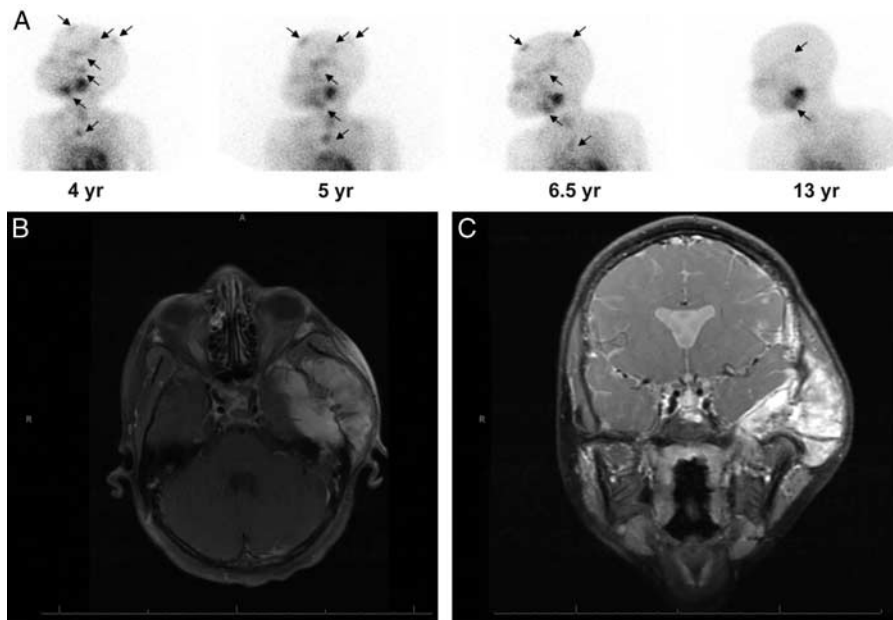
Imaging follow-up of patient 2. A, ^{123}I -MIBG scans of patient 2, performed 4, 5, 6.5, and 13 years after diagnosis. Pathologic uptake is marked by arrows. At the last ^{123}I -MIBG scan there was still pathologic uptake at the left temporal bone, right parietal bone, and both femora. Suspected uptake was seen at the right mandibular angle and at a rib. B and C, T1 (2B) and T2 (2C) weighted MRI with gadolinium contrast showing a large metastasis in the left temporal bone, 11.5 years after diagnosis. ^{123}I -MIBG indicates iodine-123-metaiodobenzylguanidine; MRI, magnetic resonance imaging.
